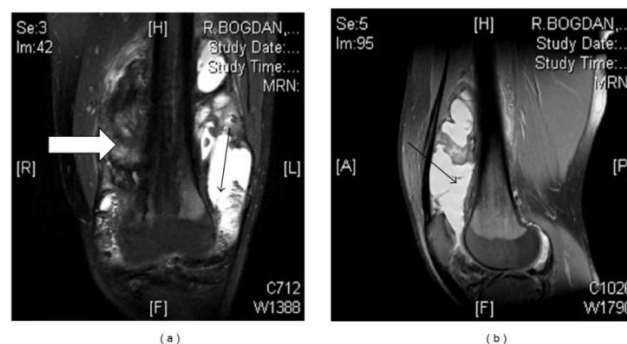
MRI findings of hemarthrosis in a 27-year-old patient with hemophilia. Anteroposterior view (a) shows intra-articular blood on the lateral side (black arrow) and severe synovitis medially (white arrow). Lateral view (b) demonstrates the same hemarthrosis (black arrow). (E. C. Rodriguez-Merchan, 2012)
